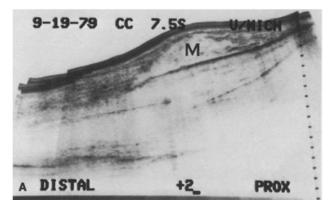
Case 13. Lipoma. 66-year-old woman with soft tissue mass of arm. Sagittal scan showing 9 cm solid mass (M) adjacent to humerus. The extent of this mass was not appreciated radiographically
